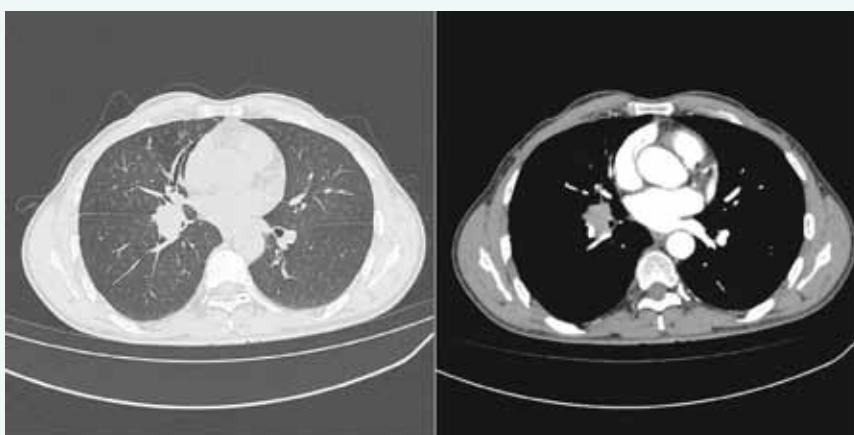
Chest CT plain scan + enhancement on September 8, 2023. Large right hilar shadow with a soft tissue mass, unclear boundaries and surrounding adjacent blood vessels, with a size of approximately 3.0 cm × 2.3 cm and a CT value of approximately 39 HU. (Compared with the previous films on July 14, 2023, the but the overall volume of the mass seemed to be increased.)
